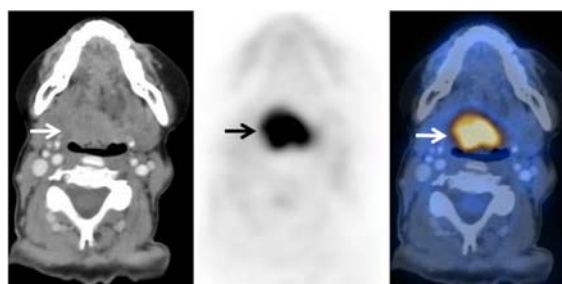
Base of the tongue (BOT) cancer in a 79-year-old female presented with right BOT mass. Axial images of a PET/CT scan shows intense FDG uptake ($SUV_{max} 15$) corresponding with a large, lobulated enhancing mass at the BOT on contrast enhanced HRCT scan, consistent with malignant process. These findings proved to be squamous cell carcinoma
